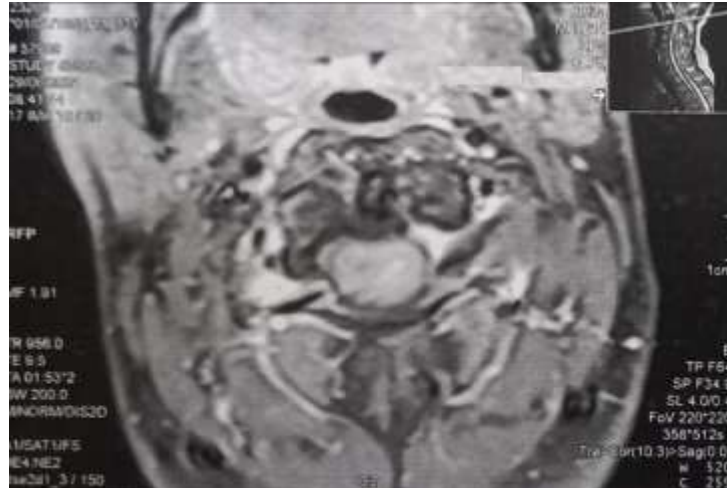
Preoperative Spinal MRI showing bulbomedullary lesion in axial T2 hypersignal.
